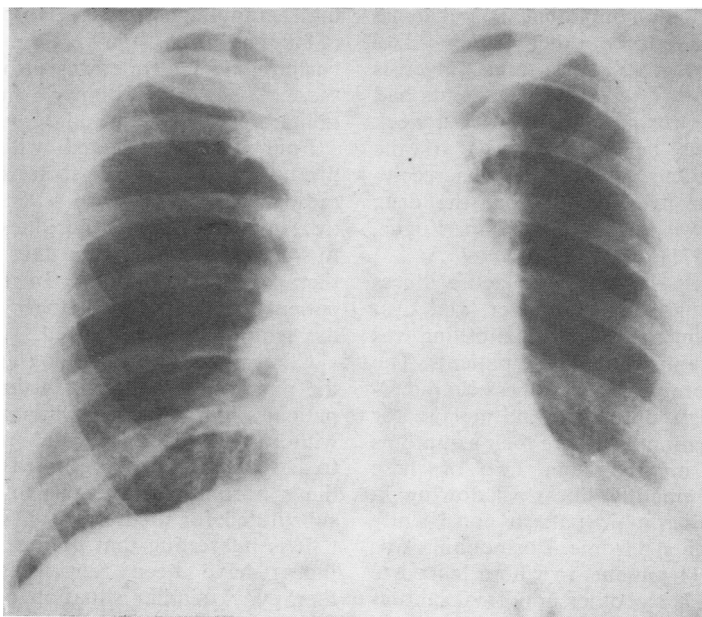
Chest radiograph taken one week later demonstrating clearing of the mottling.*
